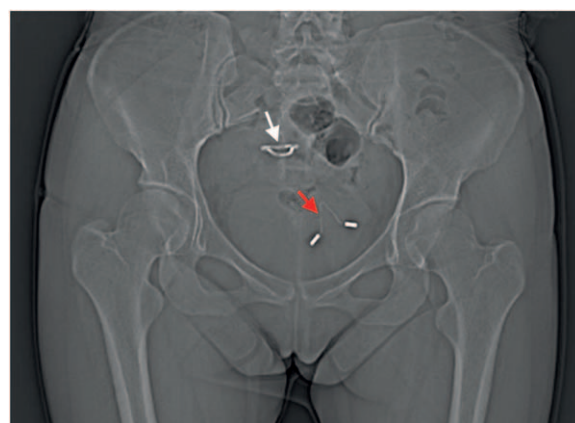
Plain radiography showing one general intrauterine device (IUD) (white arrow) and the MCu IUD (red arrow) in the pelvic cavity. IUD = intrauterine contraceptive device.
